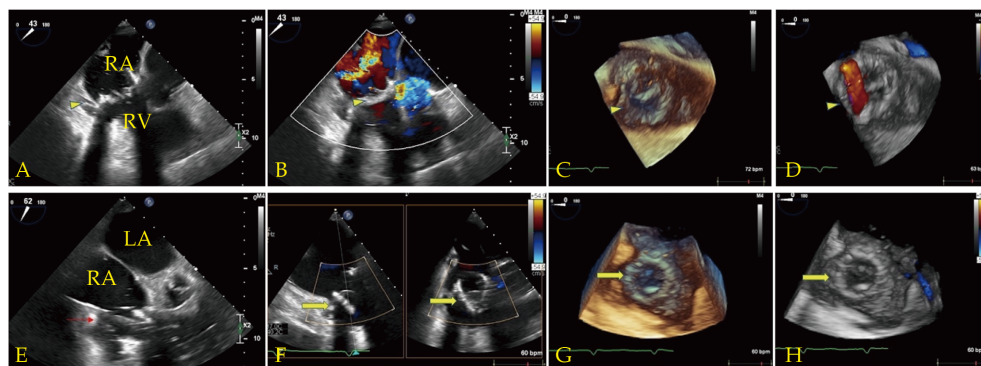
TEE-guided tricuspid valve-in-valve implantation. (A): 2DTEE demonstrating bioprosthesis valve in tricuspid position; (B): 2DTEE with color doppler imaging demonstrating severe tricuspid regurgitation; (C): 3DTEE demonstrating bioprosthesis valve in tricuspid position; (D): 3DTEE with color doppler imaging demonstrating severe tricuspid regurgitation; (E): 2DTEE demonstrating the deployment of the transcatheter bioprosthesis tricuspid valve-in-valve; (F): 2DTEE with bi-plane mode and color doppler imaging after valve deployment demonstrating a reduction in the tricuspid regurgitation; (G): 3DTEE demonstrating bioprosthesis valve in valve in tricuspid position; (H): 3D TEE with color doppler imaging demonstrating absence tricuspid regurgitation post valve in valve implantation. Arrow head: bioprosthesis valve in tricuspid position; red arrow: catheter across tricuspid valve; yellow arrow: bioprosthesis tricuspid valve in valve. LA: left atrium; RA: right atrium; RV: right ventricle.
